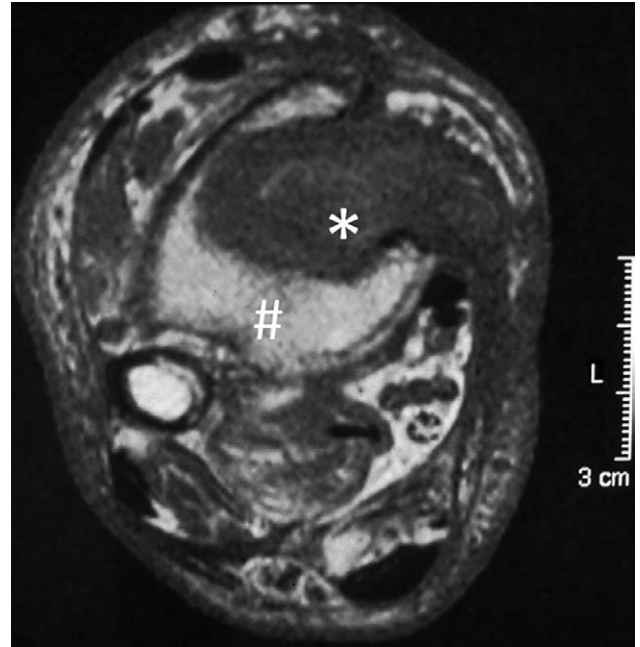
MRI 6 months postoperative. # Large bone defect of the distal tibia; *sealed with vital muscle cuff.
